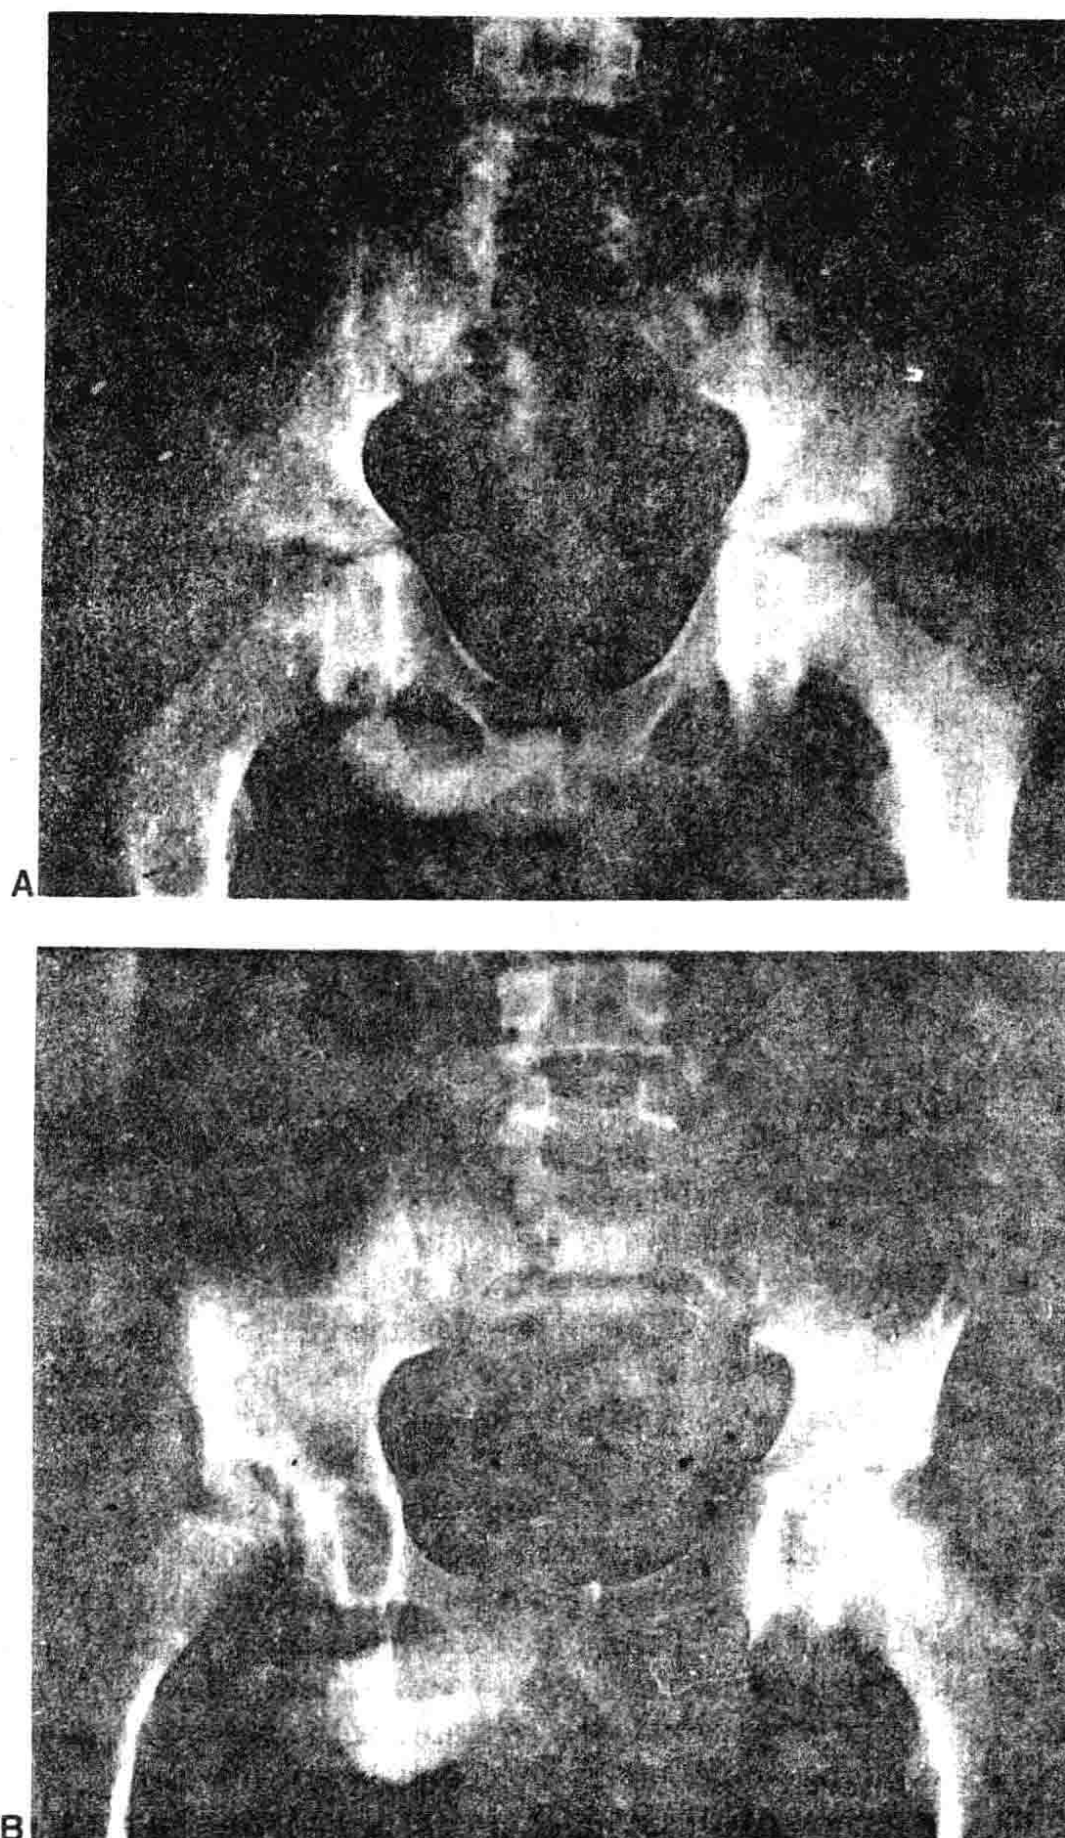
A 7-year-old boy sustained an injury to the lateral aspect of the right hip. (A) Radiograph taken at the time of injury was read as normal. (B) Patient returned at age 16 with a bump in the lateral aspect of the right hip, and was found to have subluxation of the hip and premature closure of the triradiate cartilage.
